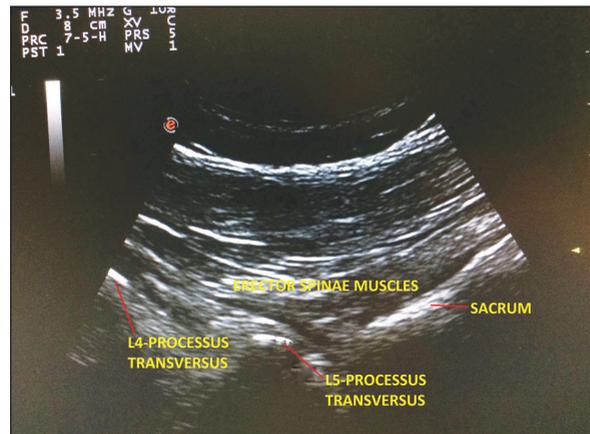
Anatomy under ultrasound (L4: Lumbar 4th vertebra, L5: Lumbar 5th vertebra).
